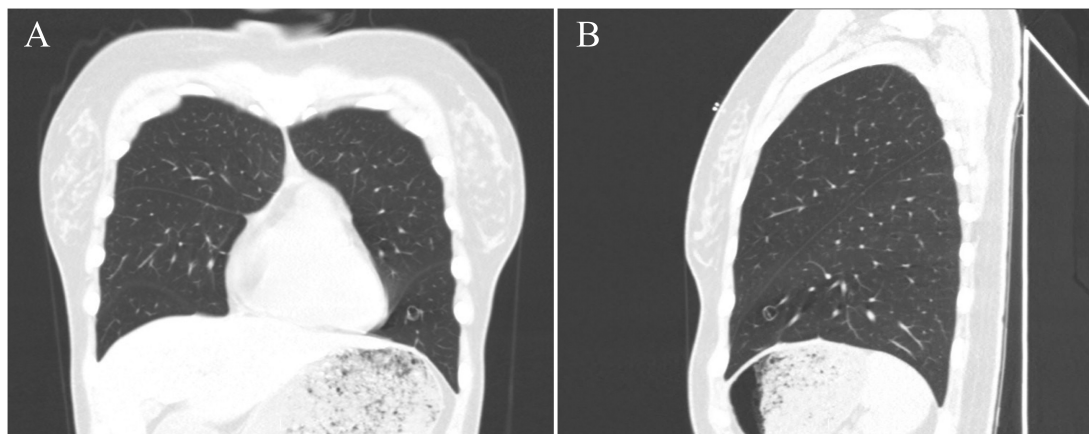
CT images of this case. CT images [(A), coronal position] [(B), sagittal position] show the tumor nodular high-density shadow in the lower lobe of the left lung, with a clear boundary, uneven internal density, and low-density vacuolar area in the center of the lesion.
